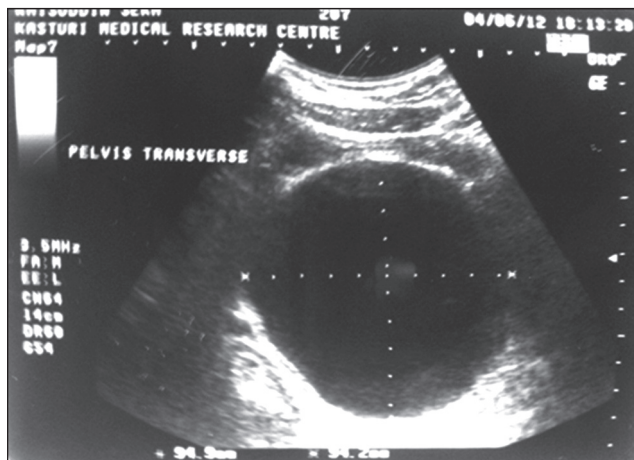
Ultrasonography showing the cyst within pelvis
